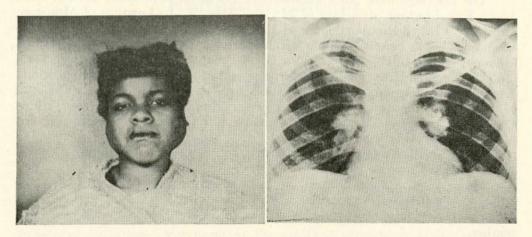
Sarcoidosis in a woman of 21 discovered during pregnancy. A. Enlarged parotid glands; swelling of right lacrymal gland (Mikulicz syndrome). B. Chest x-ray of same patient shows hilar form of sardoidosis (biopsy of breast tissue nodule, also of skin consistent with sarcoidosis; stillbirth at term).
